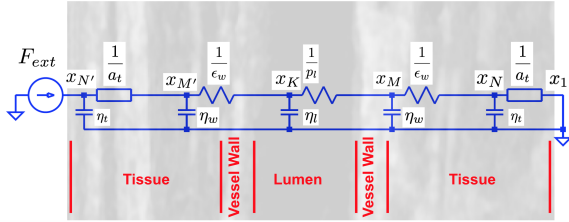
Long-axis carotid image with system model and different constitutive layers overlaid in blue and red, respectively. The regions in the ultrasound image correspond to the labels in red. The circuit components in blue do not perfectly align with the layers.
